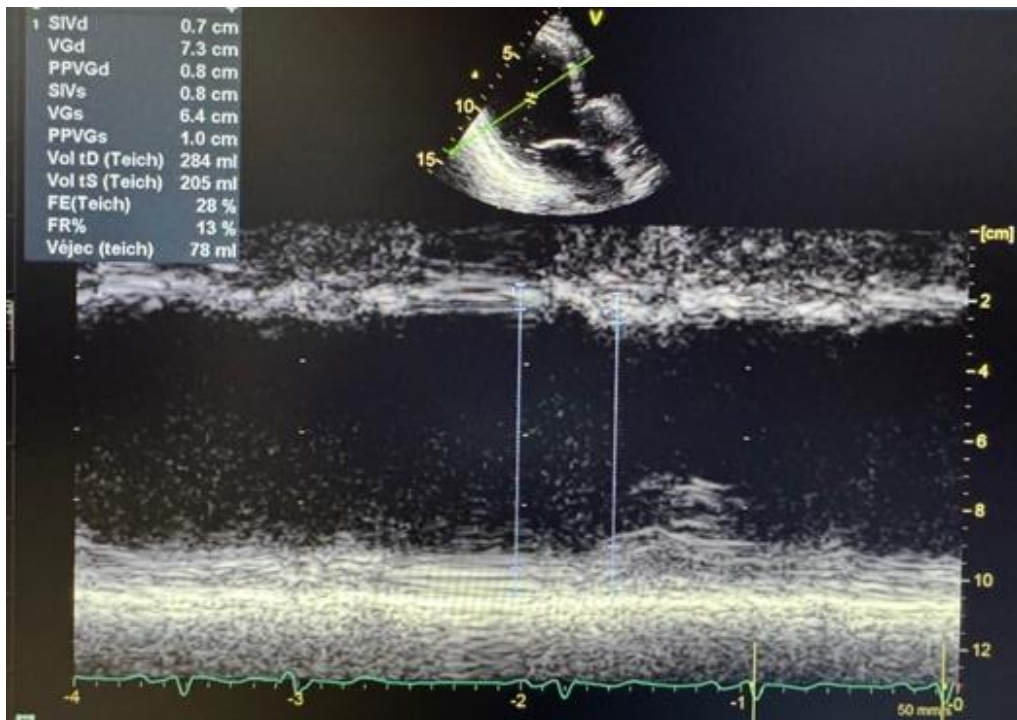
Transthoracic echocardiography in the TM section showing LV dilatation with LV systolic dysfunction
